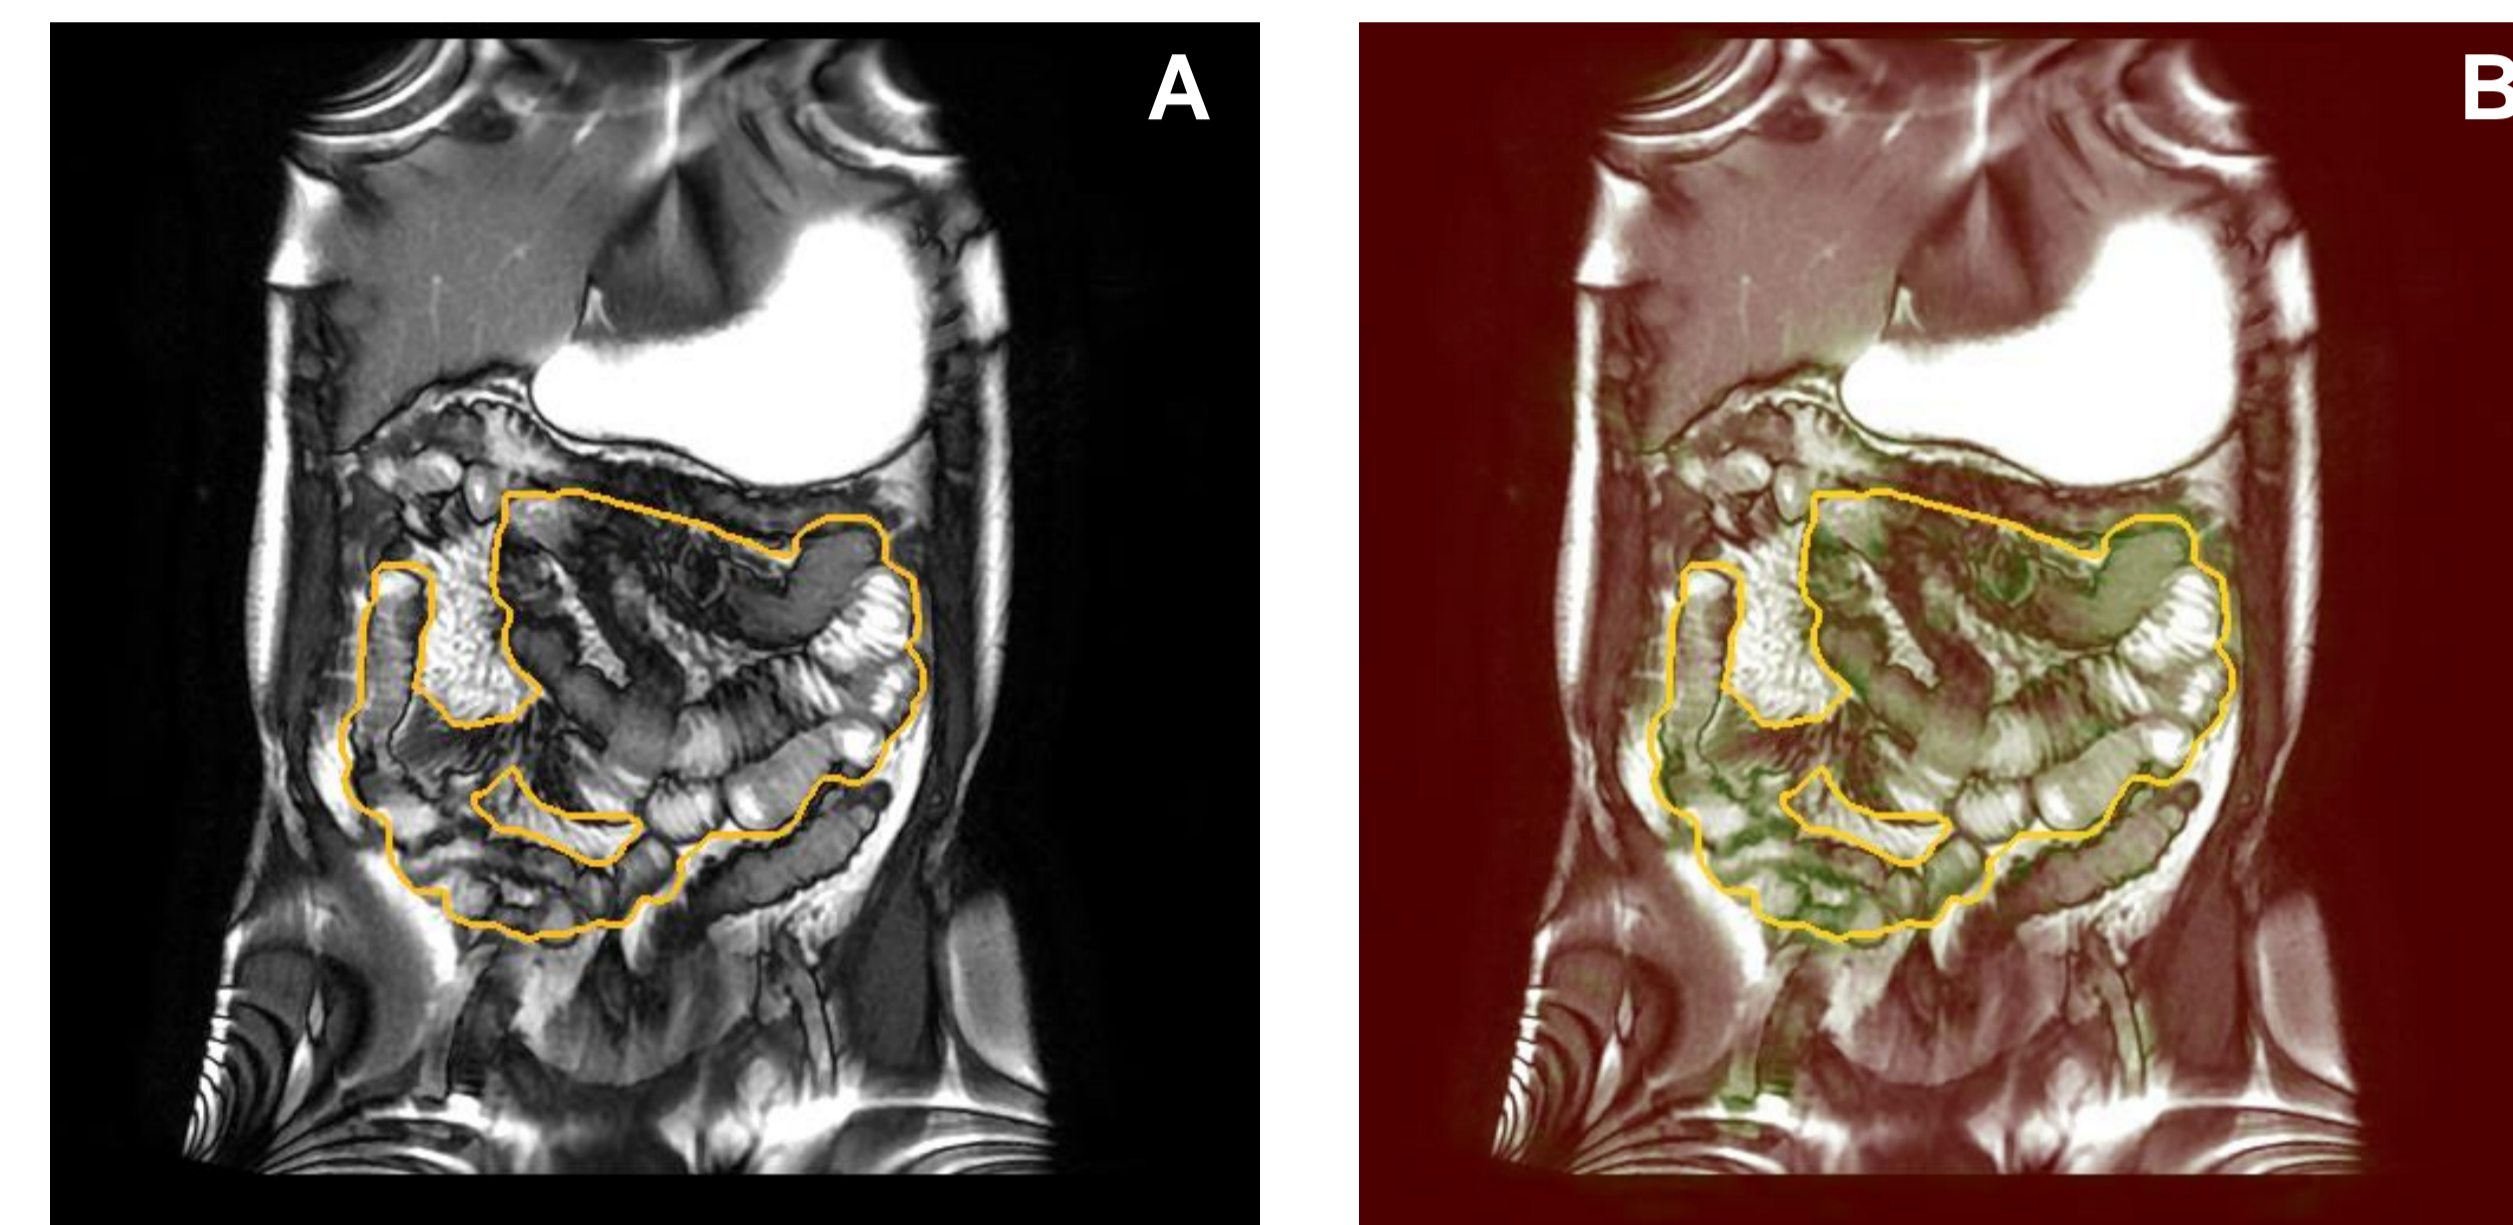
(A) Manual segmentation of small bowel areas is outlined with yellow color. (B) The motility map from Figure 2.B superimposed on the MR image. Green color indicate high motility.
